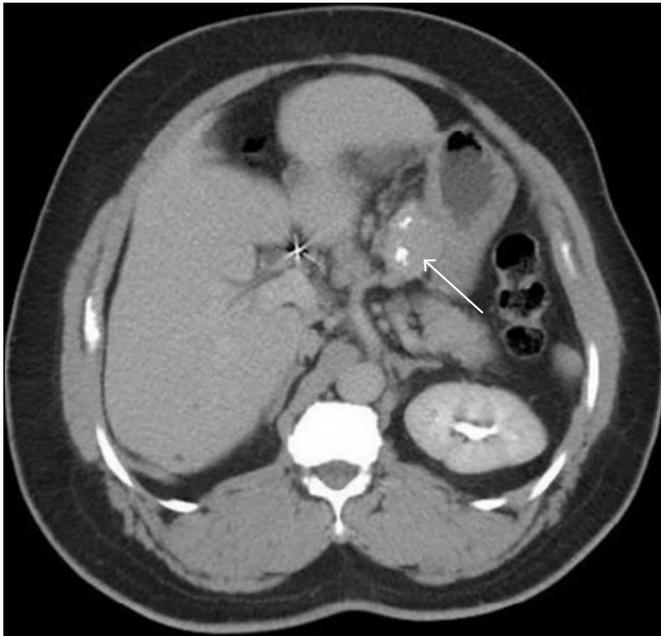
CT scan of the abdomen showing a calcified homogeneous mass measuring 3.7 cm between the pancreatic and gastric body (arrow).
